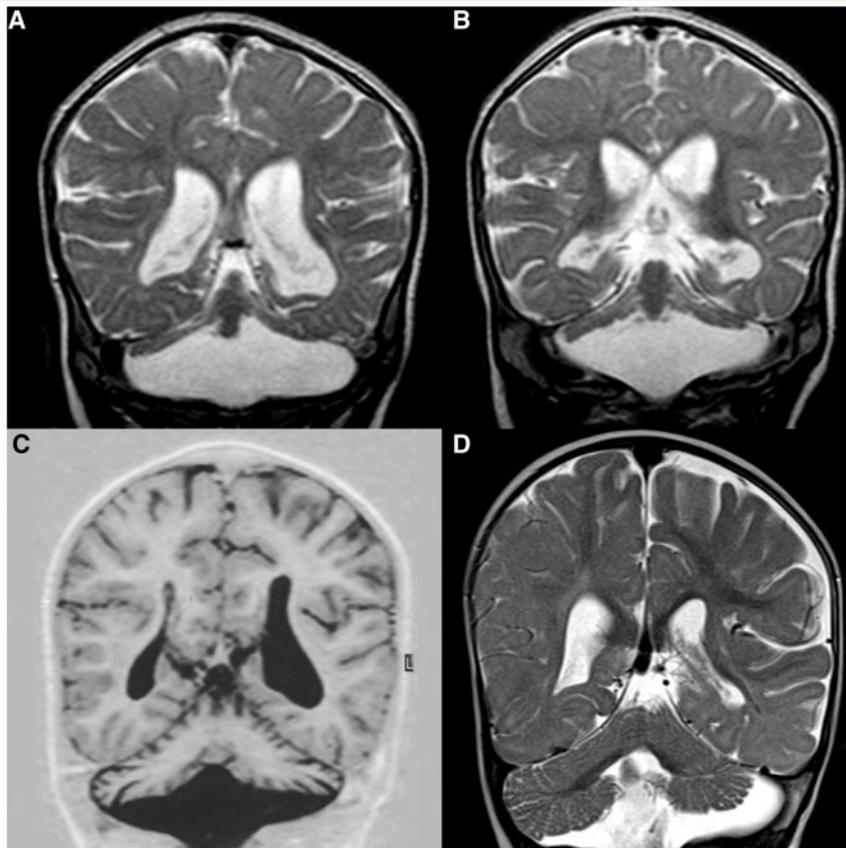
Examples of MRI scores of cerebellum. (A and B) Cerebellar hemisphere score 1: dragonfly type, with flat cerebellar hemispheres and a relatively spared cerebellar vermis (coronal sections, T₂-weighted, 9 months). Mild atrophy of the cerebral cortex with visible sulci. Homozygous for common *TSEN54* mutation. (C) Cerebellar hemisphere score 2: butterfly type, with hypoplastic cerebellar hemispheres. Decrease in size of the vermis is proportional to the diminution in size of the hemispheres (coronal section, T₁-weighted, 7 years). In addition, cerebellar cortical atrophy is seen, as well as mild atrophy of the cerebral cortex with visible sulci. No mutation identified. (D) Cerebellar hemisphere score 3: postnatal atrophy-like on the right side, combined with mild cerebellar hypoplasia on the left (coronal section, T₂-weighted, 10 months). In addition there is cerebral cortical atrophy with visible sulci. Heterozygote for uncommon *TSEN54* mutation (p.G124V) plus heterozygote for common *TSEN54* mutation.
